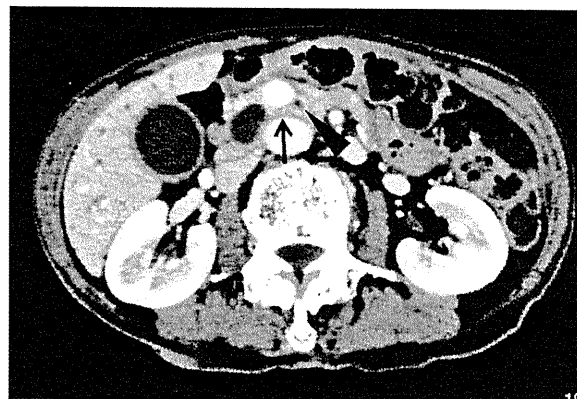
Dynamic CT imaging showing pancreatic tissue completely encircling the superior mesenteric vein (SMV; arrow) and a dilated main pancreatic duct in the tissue behind the SMV (arrow head).
